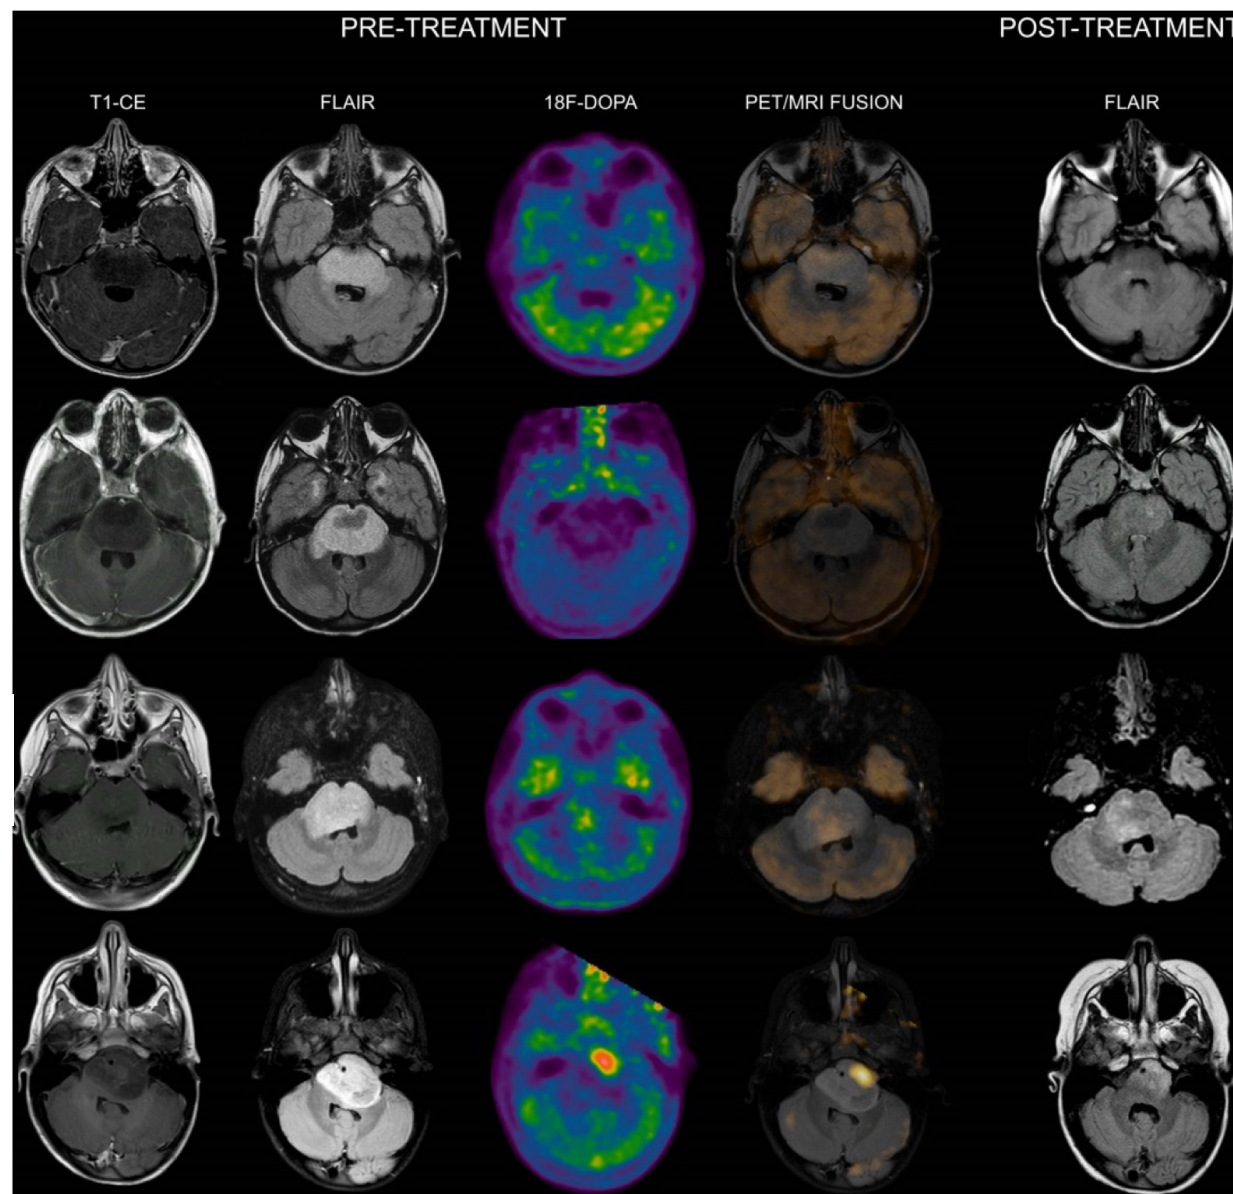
Co-registered and fused MRI and ^{18}F -DOPA PET images of DIPGs with T/S ≤ 1 .
